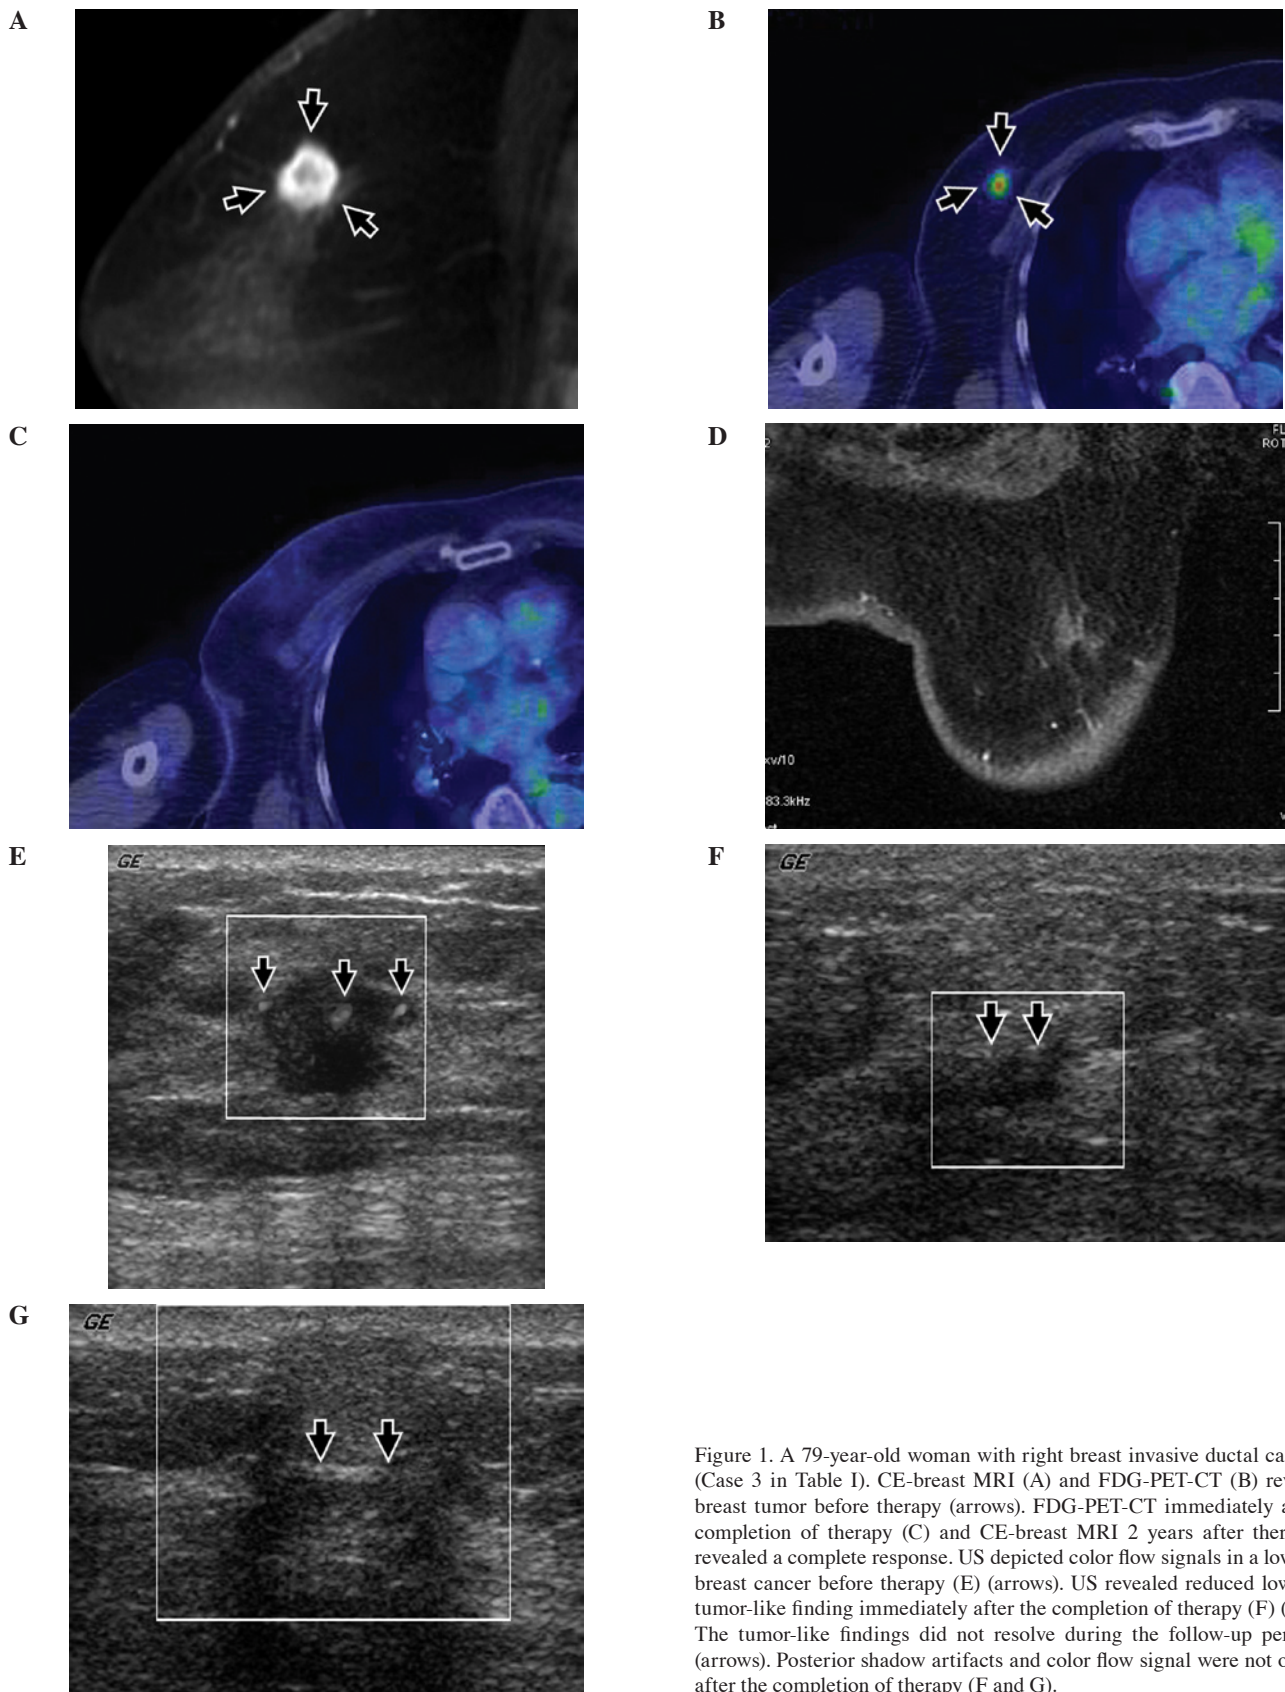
A 79-year-old woman with right breast invasive ductal carcinoma (Case 3 in Table I). CE-breast MRI (A) and FDG-PET-CT (B) revealed a breast tumor before therapy (arrows). FDG-PET-CT immediately after the completion of therapy (C) and CE-breast MRI 2 years after therapy (D) revealed a complete response. US depicted color flow signals in a low echoic breast cancer before therapy (E) (arrows). US revealed reduced low echoic tumor-like finding immediately after the completion of therapy (F) (arrows). The tumor-like findings did not resolve during the follow-up period (G) (arrows). Posterior shadow artifacts and color flow signal were not observed after the completion of therapy (F and G).
